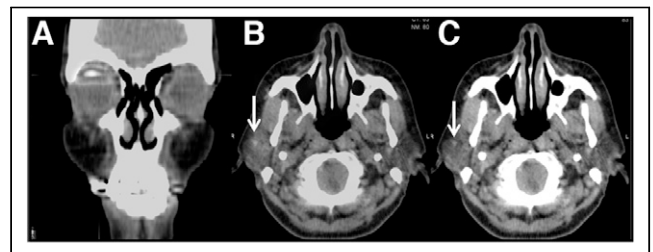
$^{99\text{m}}\text{Tc}$ -filtered sulfur colloid SPECT/CT (case 2). (A) Coronal PET/MR image demonstrating successful radiotracer injection to right-eye subconjunctival region by ophthalmologist. (B) Axial PET/MR image. (C) Axial low-dose CT image. Tiny sentinel lymph node (arrows) was identified in right fossa of parotid gland. Node was negative for metastasis on biopsy. Color version of this figure is available as supplemental file at <http://tech.snmjournals.org>.
